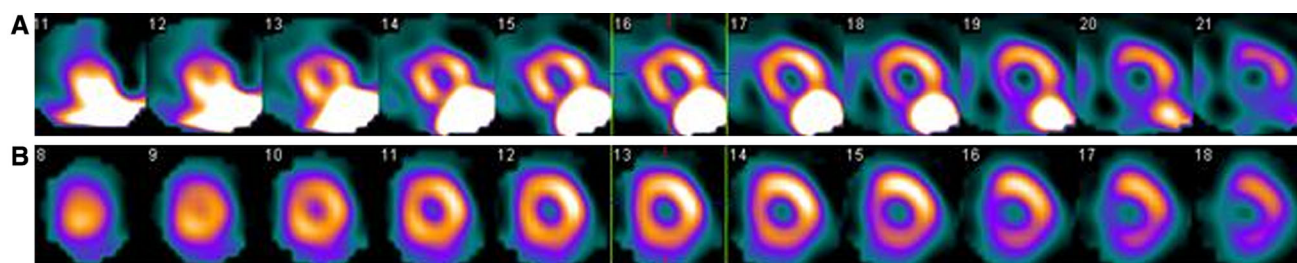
a Adenosine stress SPECT shows interfering intestinal activity. b Repeated SPECT in the same patient shows normal MPI after ingestion of carbonated water and delayed imaging
